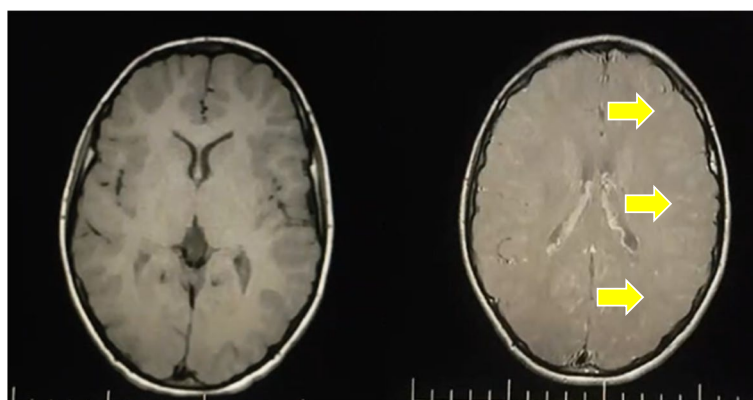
A, B Brain magnetic resonance images: pre- and post-contrast axial T1 images show subtle pial contrast enhancement (arrows)
